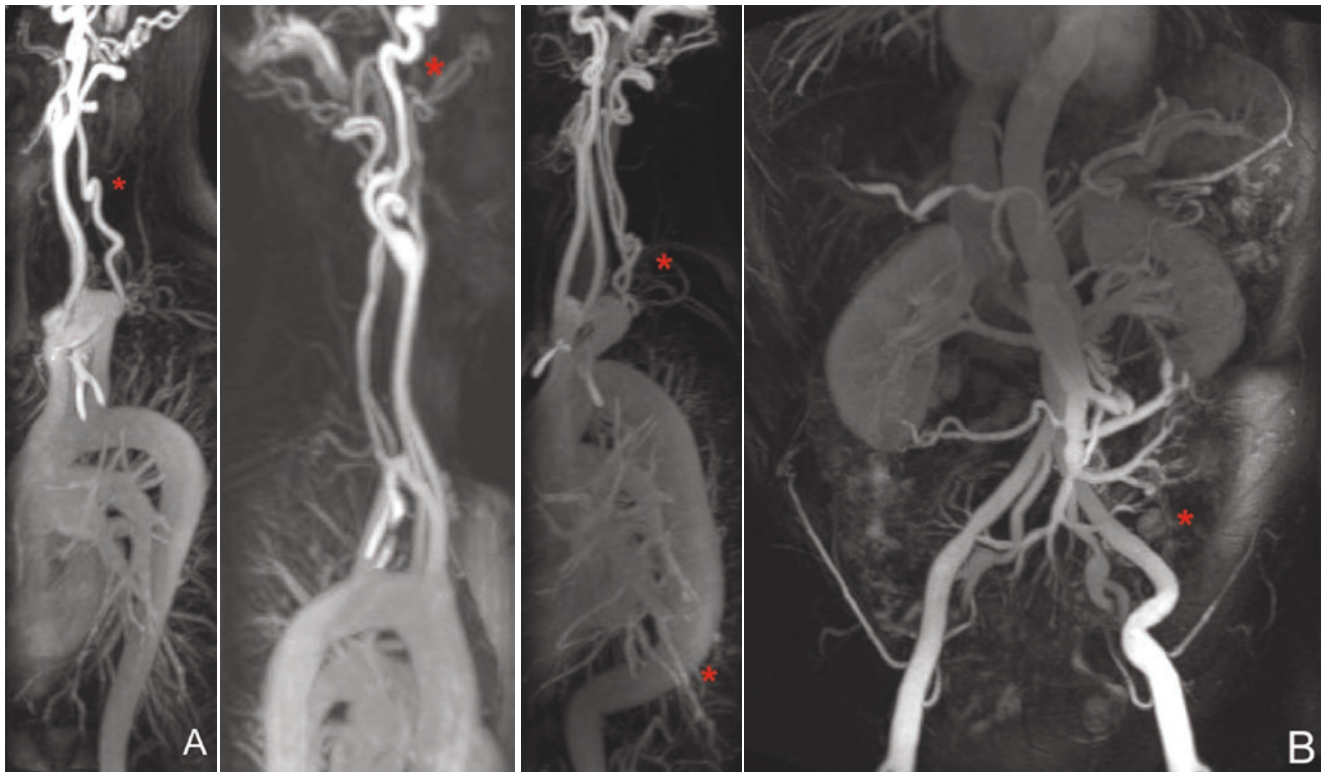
MRI images of the head and neck vessels in two sisters with a *TGFBR2* mutation (panel A) and of the upper thoracic aorta and head and neck vessels as well as the lower abdominal aorta and iliac arteries
